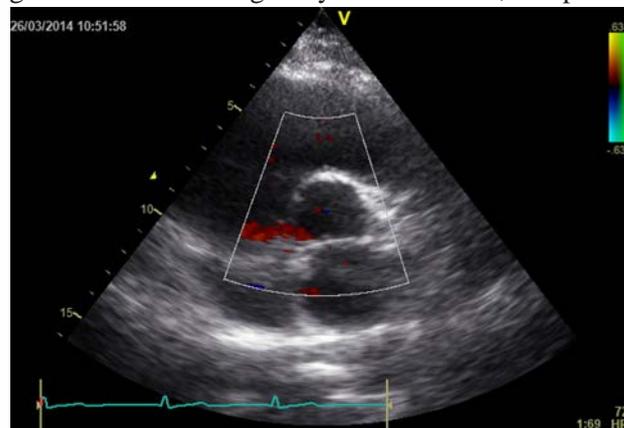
Transthoracic echocardiogram depicting aortic valve, prosthesis of A. ascendens, atria and right ventricle.
